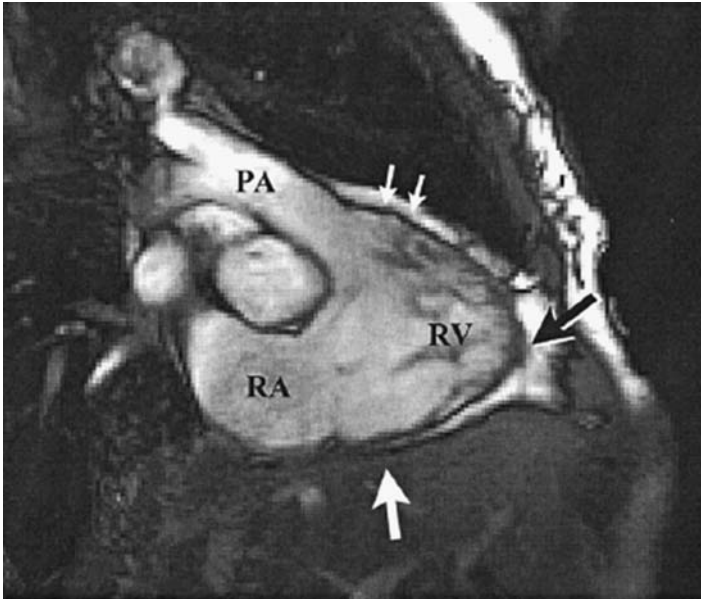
MRI image in the oblique sagittal plane showing the *triangle of dysplasia*, which is constituted by the inferior subtricuspid area (thick white arrow), RV apex (black arrow), and RV infundibulum (thin white arrows). RA, right atrium; PA, pulmonary artery.
